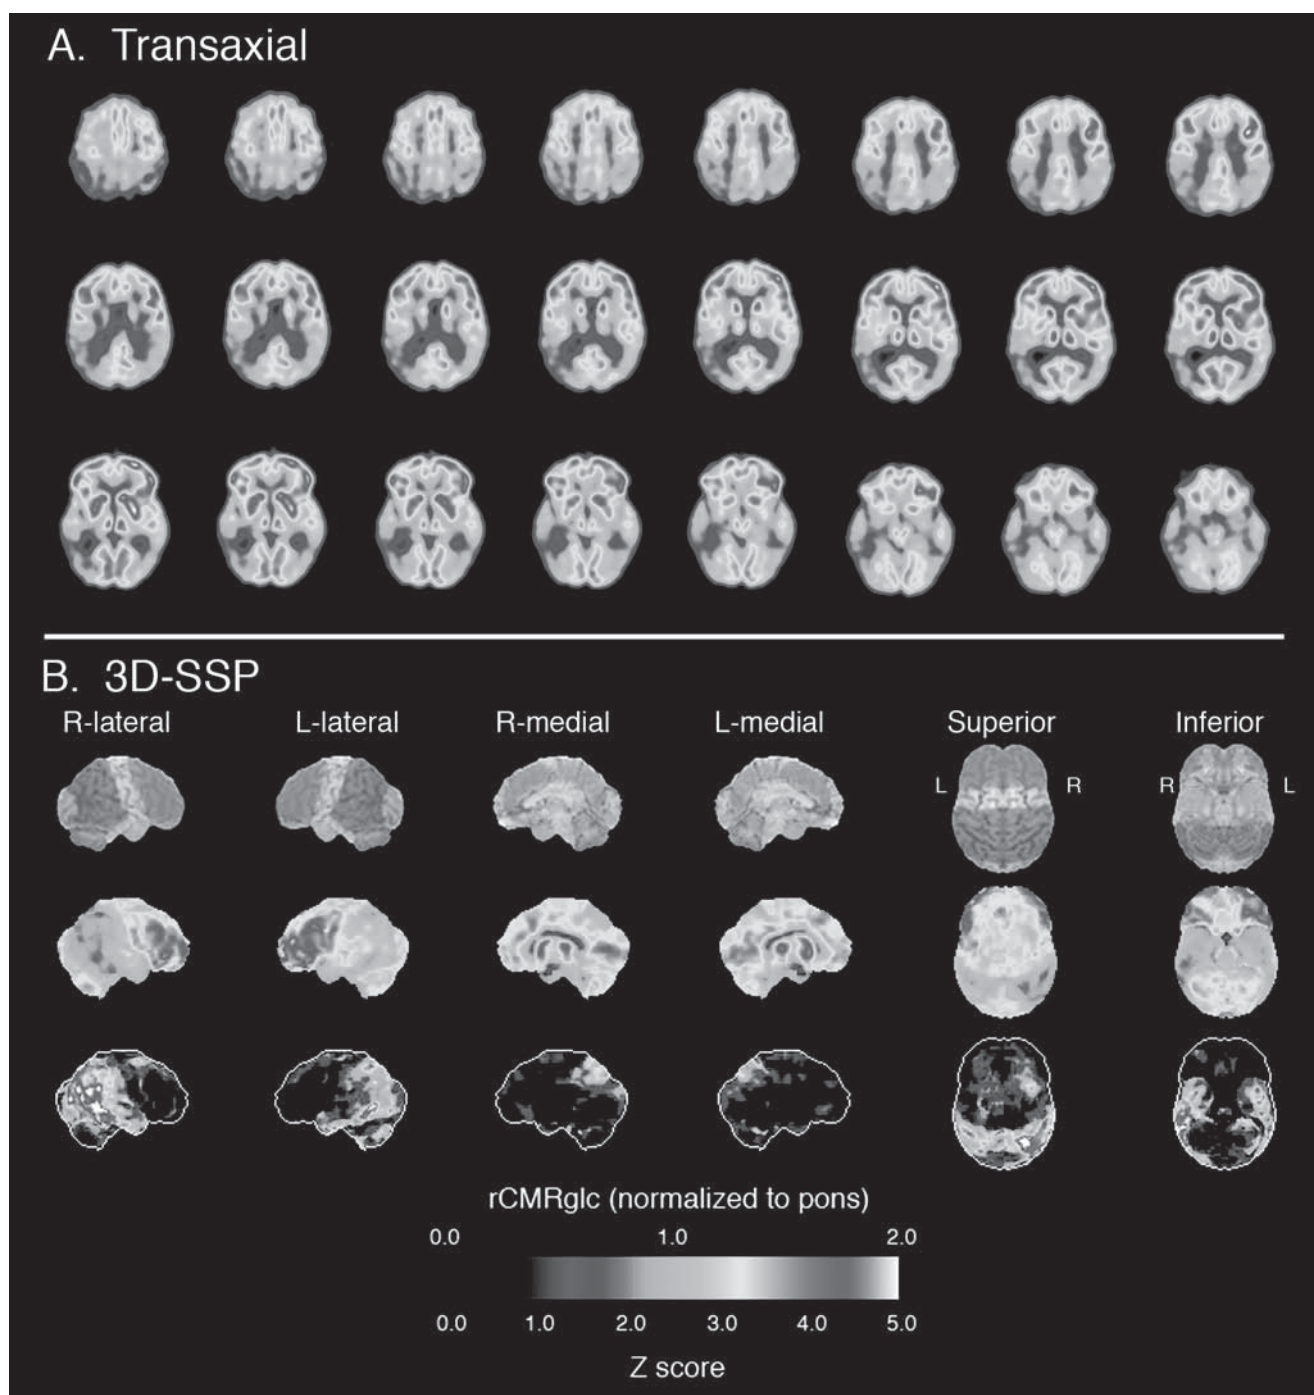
Fluorodeoxyglucose positron emission tomography (FDG-PET) in a patient with Alzheimer disease. (See color plate 2)
